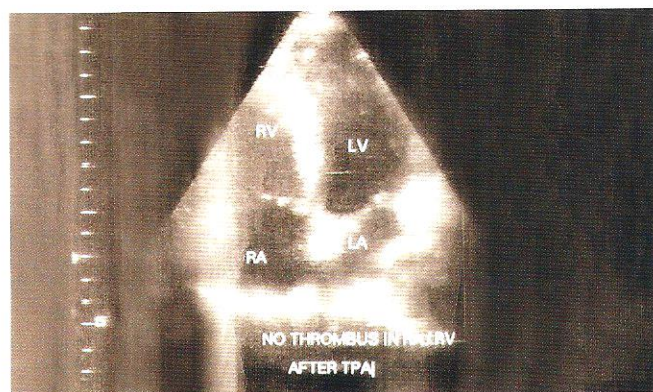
Echocardiographic four chamber view with no right atrial or ventricular thrombus after tPA therapy.
